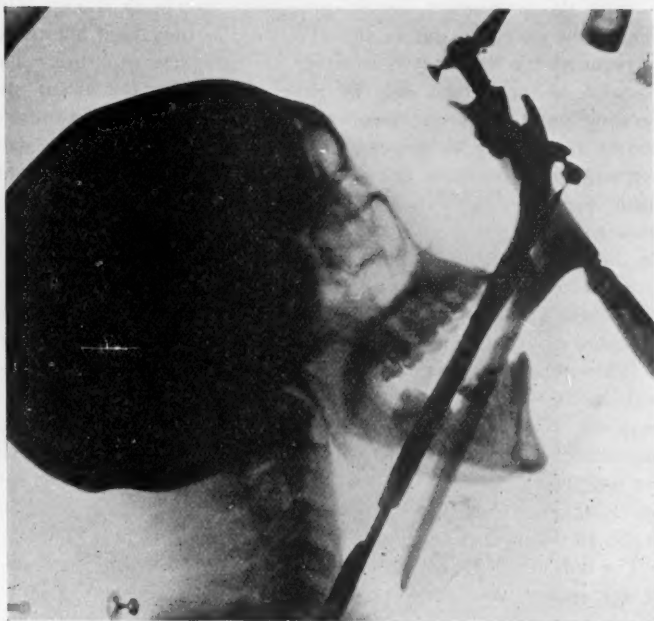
X-ray photograph of the directoscopy in place, in the sitting position, exposing the larynx completely.
